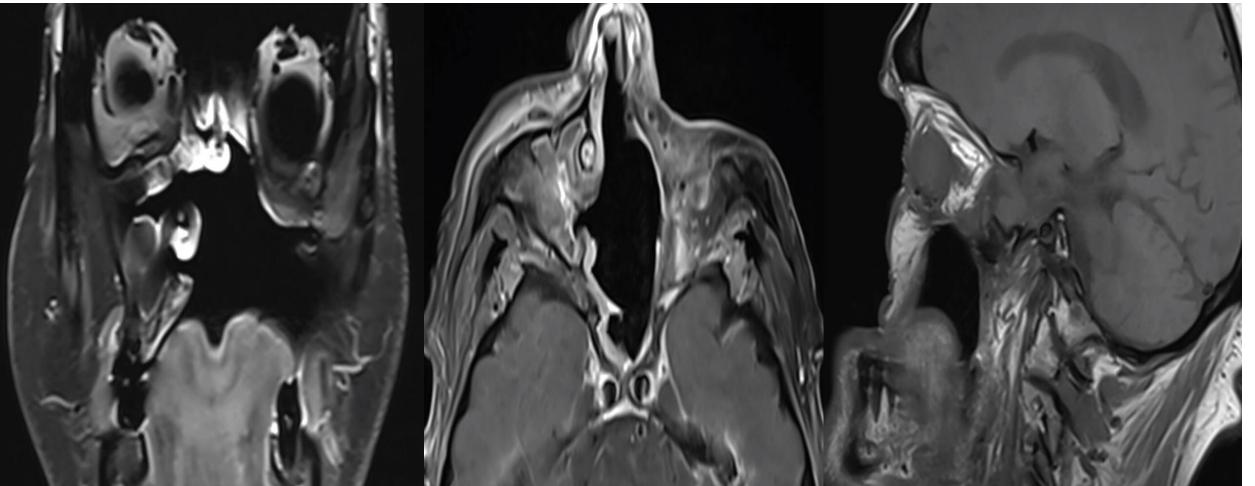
Two-year postoperative T1-weighted coronal, axial, and sagittal view
